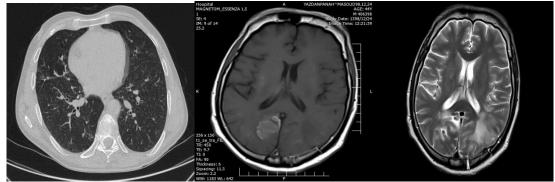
Chest CT scan and brain MRI after treatment indicating complete resolution of lung abscess and significant resolution of brain lesions.
